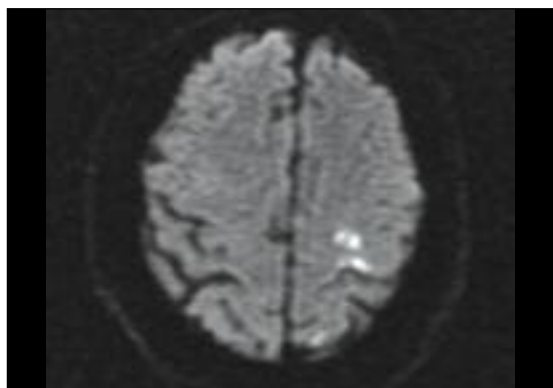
Diffusion-weighted brain MRI scan demonstrating areas of acute ischemia (bright signal abnormality) within the left sensorimotor cortex, caused by embolism from a ruptured atherosclerotic plaque within the ipsilateral internal carotid artery in the neck.
